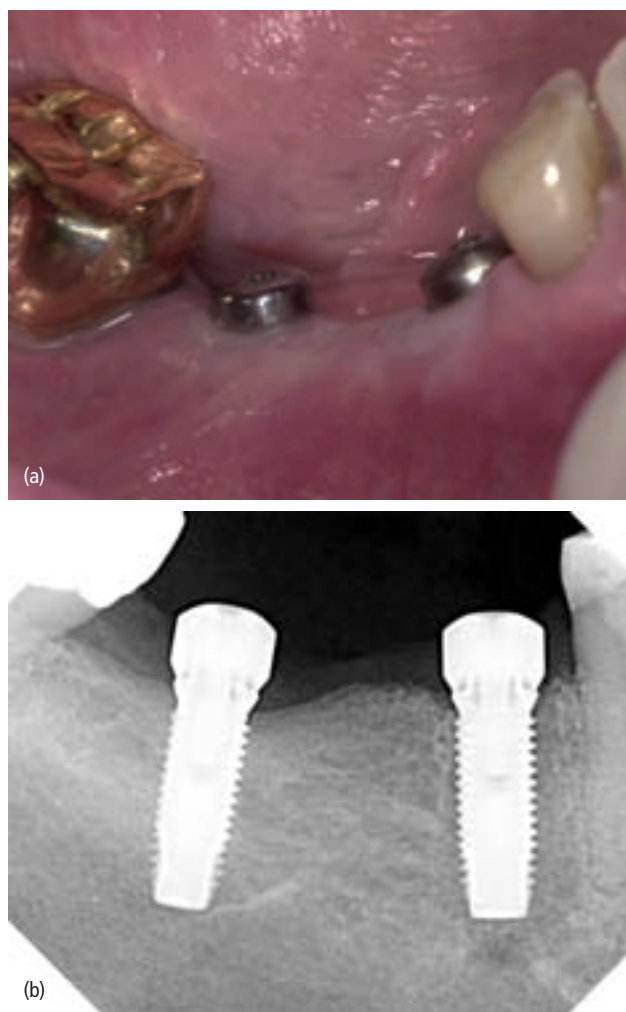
(a, b) Postoperative clinical picture showing the two implants placed as a single-phase surgery with a radiographic view.
